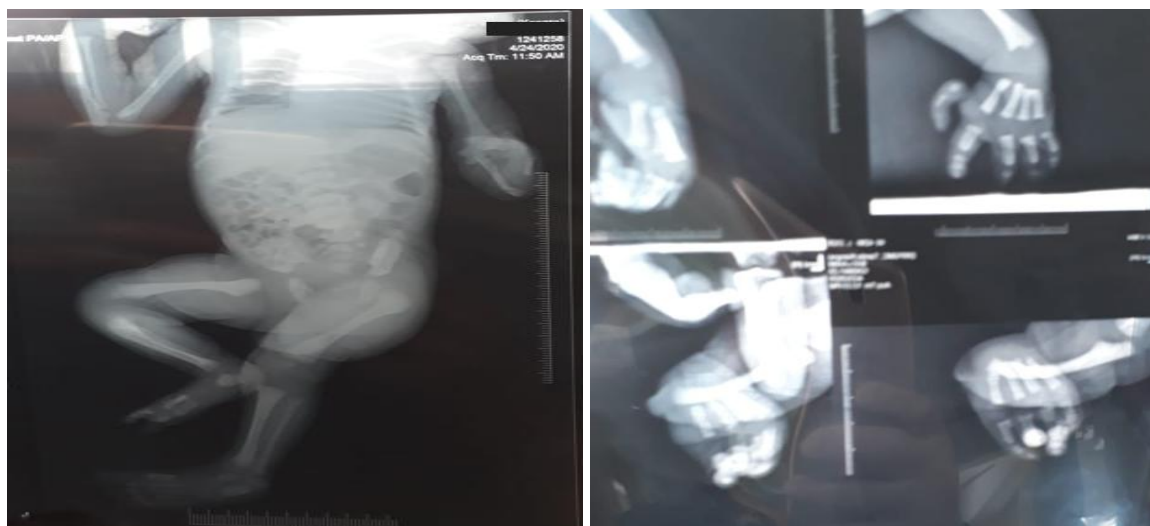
X-ray showing features of Holt Oram Syndrome
